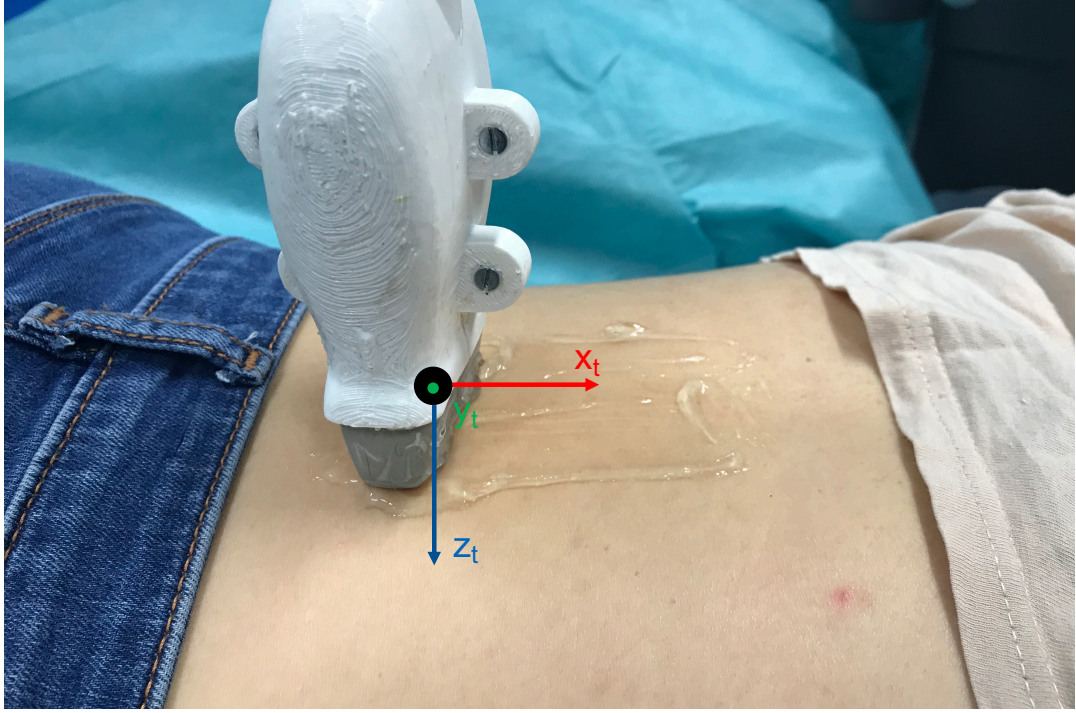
A ultrasound acquisition performed by a robotic arm. In this over-simplified example, the task can be described as sliding the ultrasound probe along the x_t axis while exerting a fixed force along z_t .
